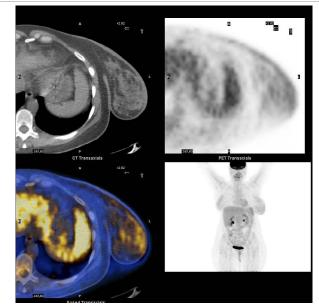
Post-operative FDG-PET: no evidence of disease recurrence.
